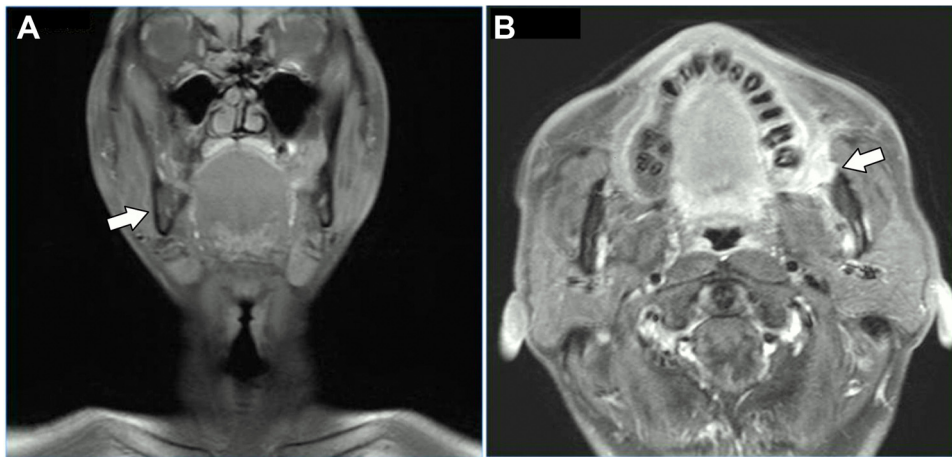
Findings in MRI.
